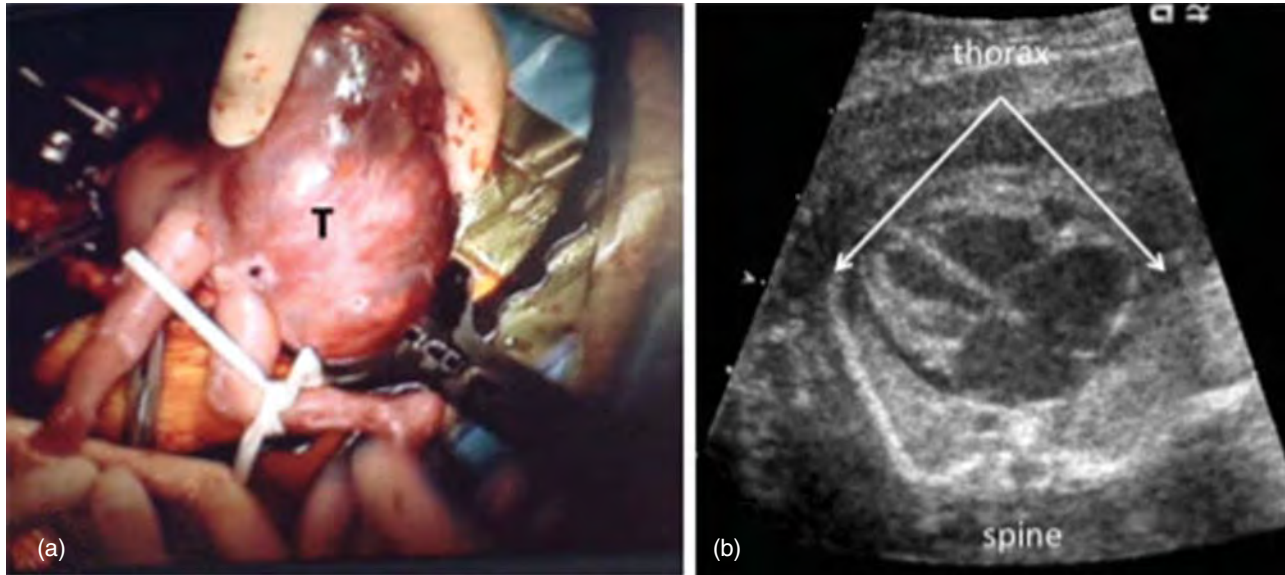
Fetus with large sacrococcygeal teratoma (SCT). (a) Intraoperative photo during fetal resection and debulking of the tumor (T); (b) Preoperative fetal echocardiography demonstrating cardiomegaly and pericardial effusion associated with impending hydrops because of high cardiac output. SCT is a germ cell tumor originating at the coccyx and growing outward and often occupying the fetal pelvis and abdomen that can grow to a substantial and highly vascular mass. SCT can cause high output cardiac failure because of increased preload which is exacerbated by its typically low vascular resistance which can compete with blood flow to placenta. With large SCT, the cardiac findings are ventricular hypertrophy and dilatation, with reduction in systolic function, atrioventricular valve regurgitation with development of hydrops and risk of fetal demise. Fetal surgical intervention or early delivery may be indicated for severe cases.
